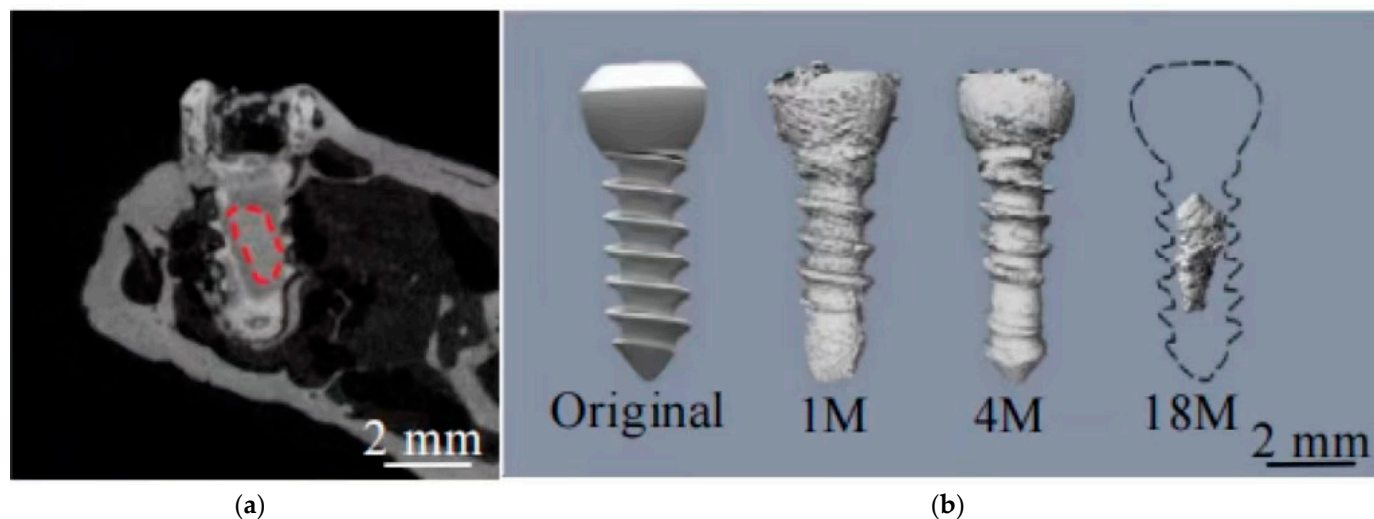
CT scans and 3D reconstruction of JDBM screw after 18 months implantation: (a) CT image of implanted screw (the original screw is marked by a red dashed line); (b) the original screw and segmented residual screw at 1, 4, and 18 months post-operation [200]. Reprinted with permission from [200]. 2016, Elsevier.
